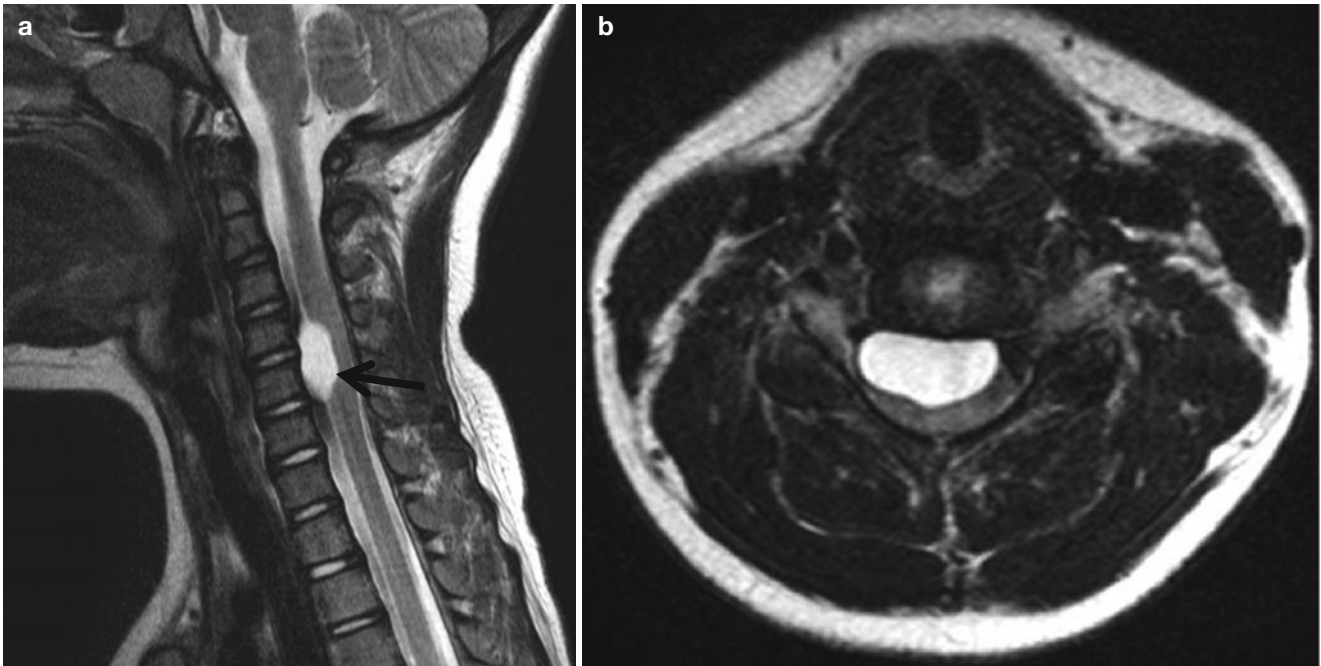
Neurenteric cyst in a 3-year-old girl. (a) T2-weighted sagittal image demonstrates ovoid-shaped cyst (*arrow*), anteriorly located in the cervical spinal canal. (b) Axial image shows compressed cord by the mass
